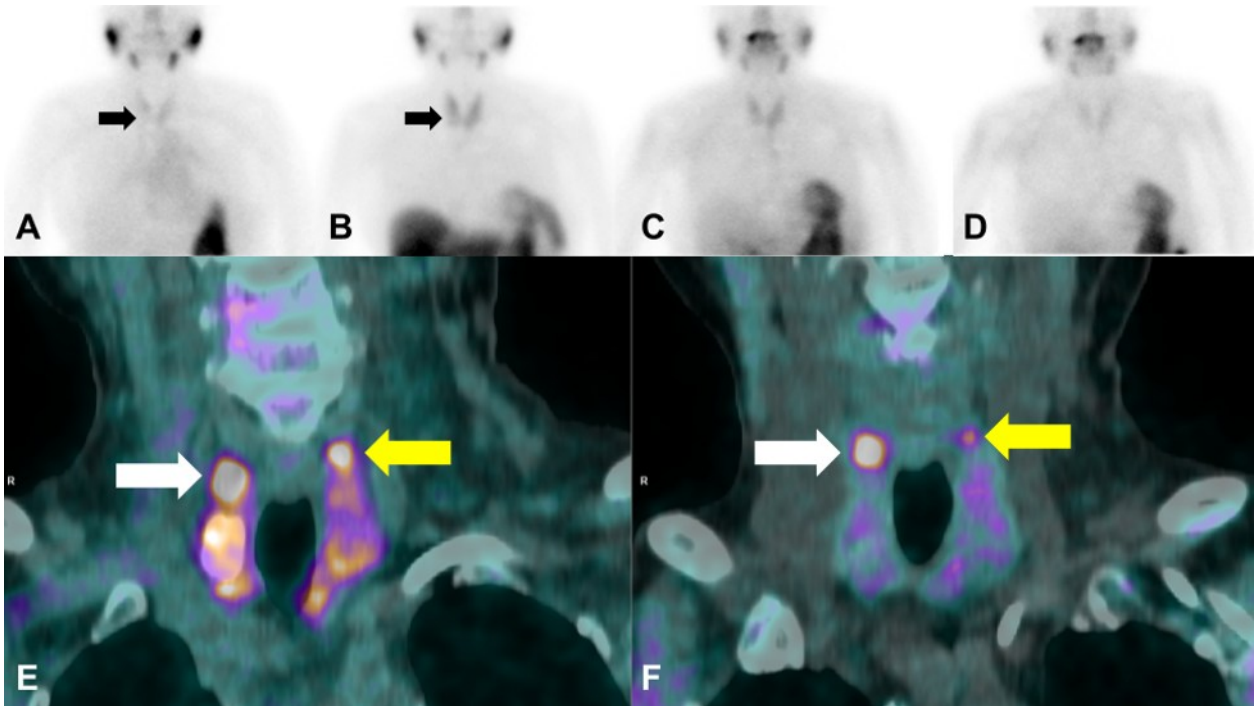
Dual-tracer, dual phase parathyroid scintigraphy showed a focus of decreased tracer uptake in the inferior third of the right thyroid lobe (black arrow) in the ^{99m}Tc-pertechnetate planar image (A). The similar focus has less sestamibi uptake compared to the rest of the thyroid gland evident in the early phase (B) and delayed phase (C, D) images. FCH PET/CT scan was done due to negative scintigraphic result and five minutes after tracer administration (E) showed FCH-avid foci posterior to the upper poles of both thyroid lobes, with an SUV of 31.6 on the right (white arrow) and 7.6 on the left (yellow arrow). Delayed fused PET/CT image one hour after tracer administration (F) showed the same FCH-avid foci with a decrease in intensity: SUVright 18.4 (white arrow) and SUVleft 4.0 (yellow arrow). These lesions measure 1.2 x 1 cm on the right and 0.8 x 0.6 cm on the left, and likely relate to hyperfunctioning parathyroid glands.
